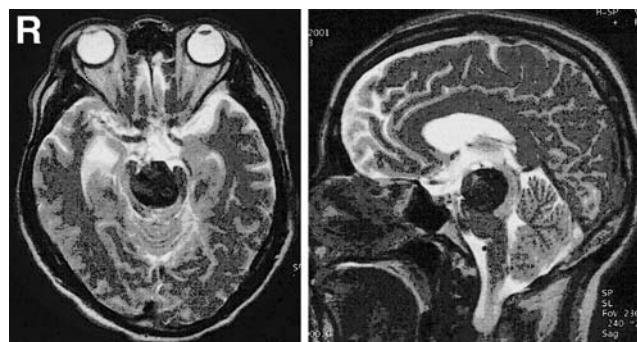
Axial (left) and sagittal (right) T₂-weighted magnetic resonance images 4 years after the initial embolization demonstrating a basilar bifurcation aneurysm with coil compaction extending into the upper midbrain. Note the brainstem edema adjacent to the aneurysm.
